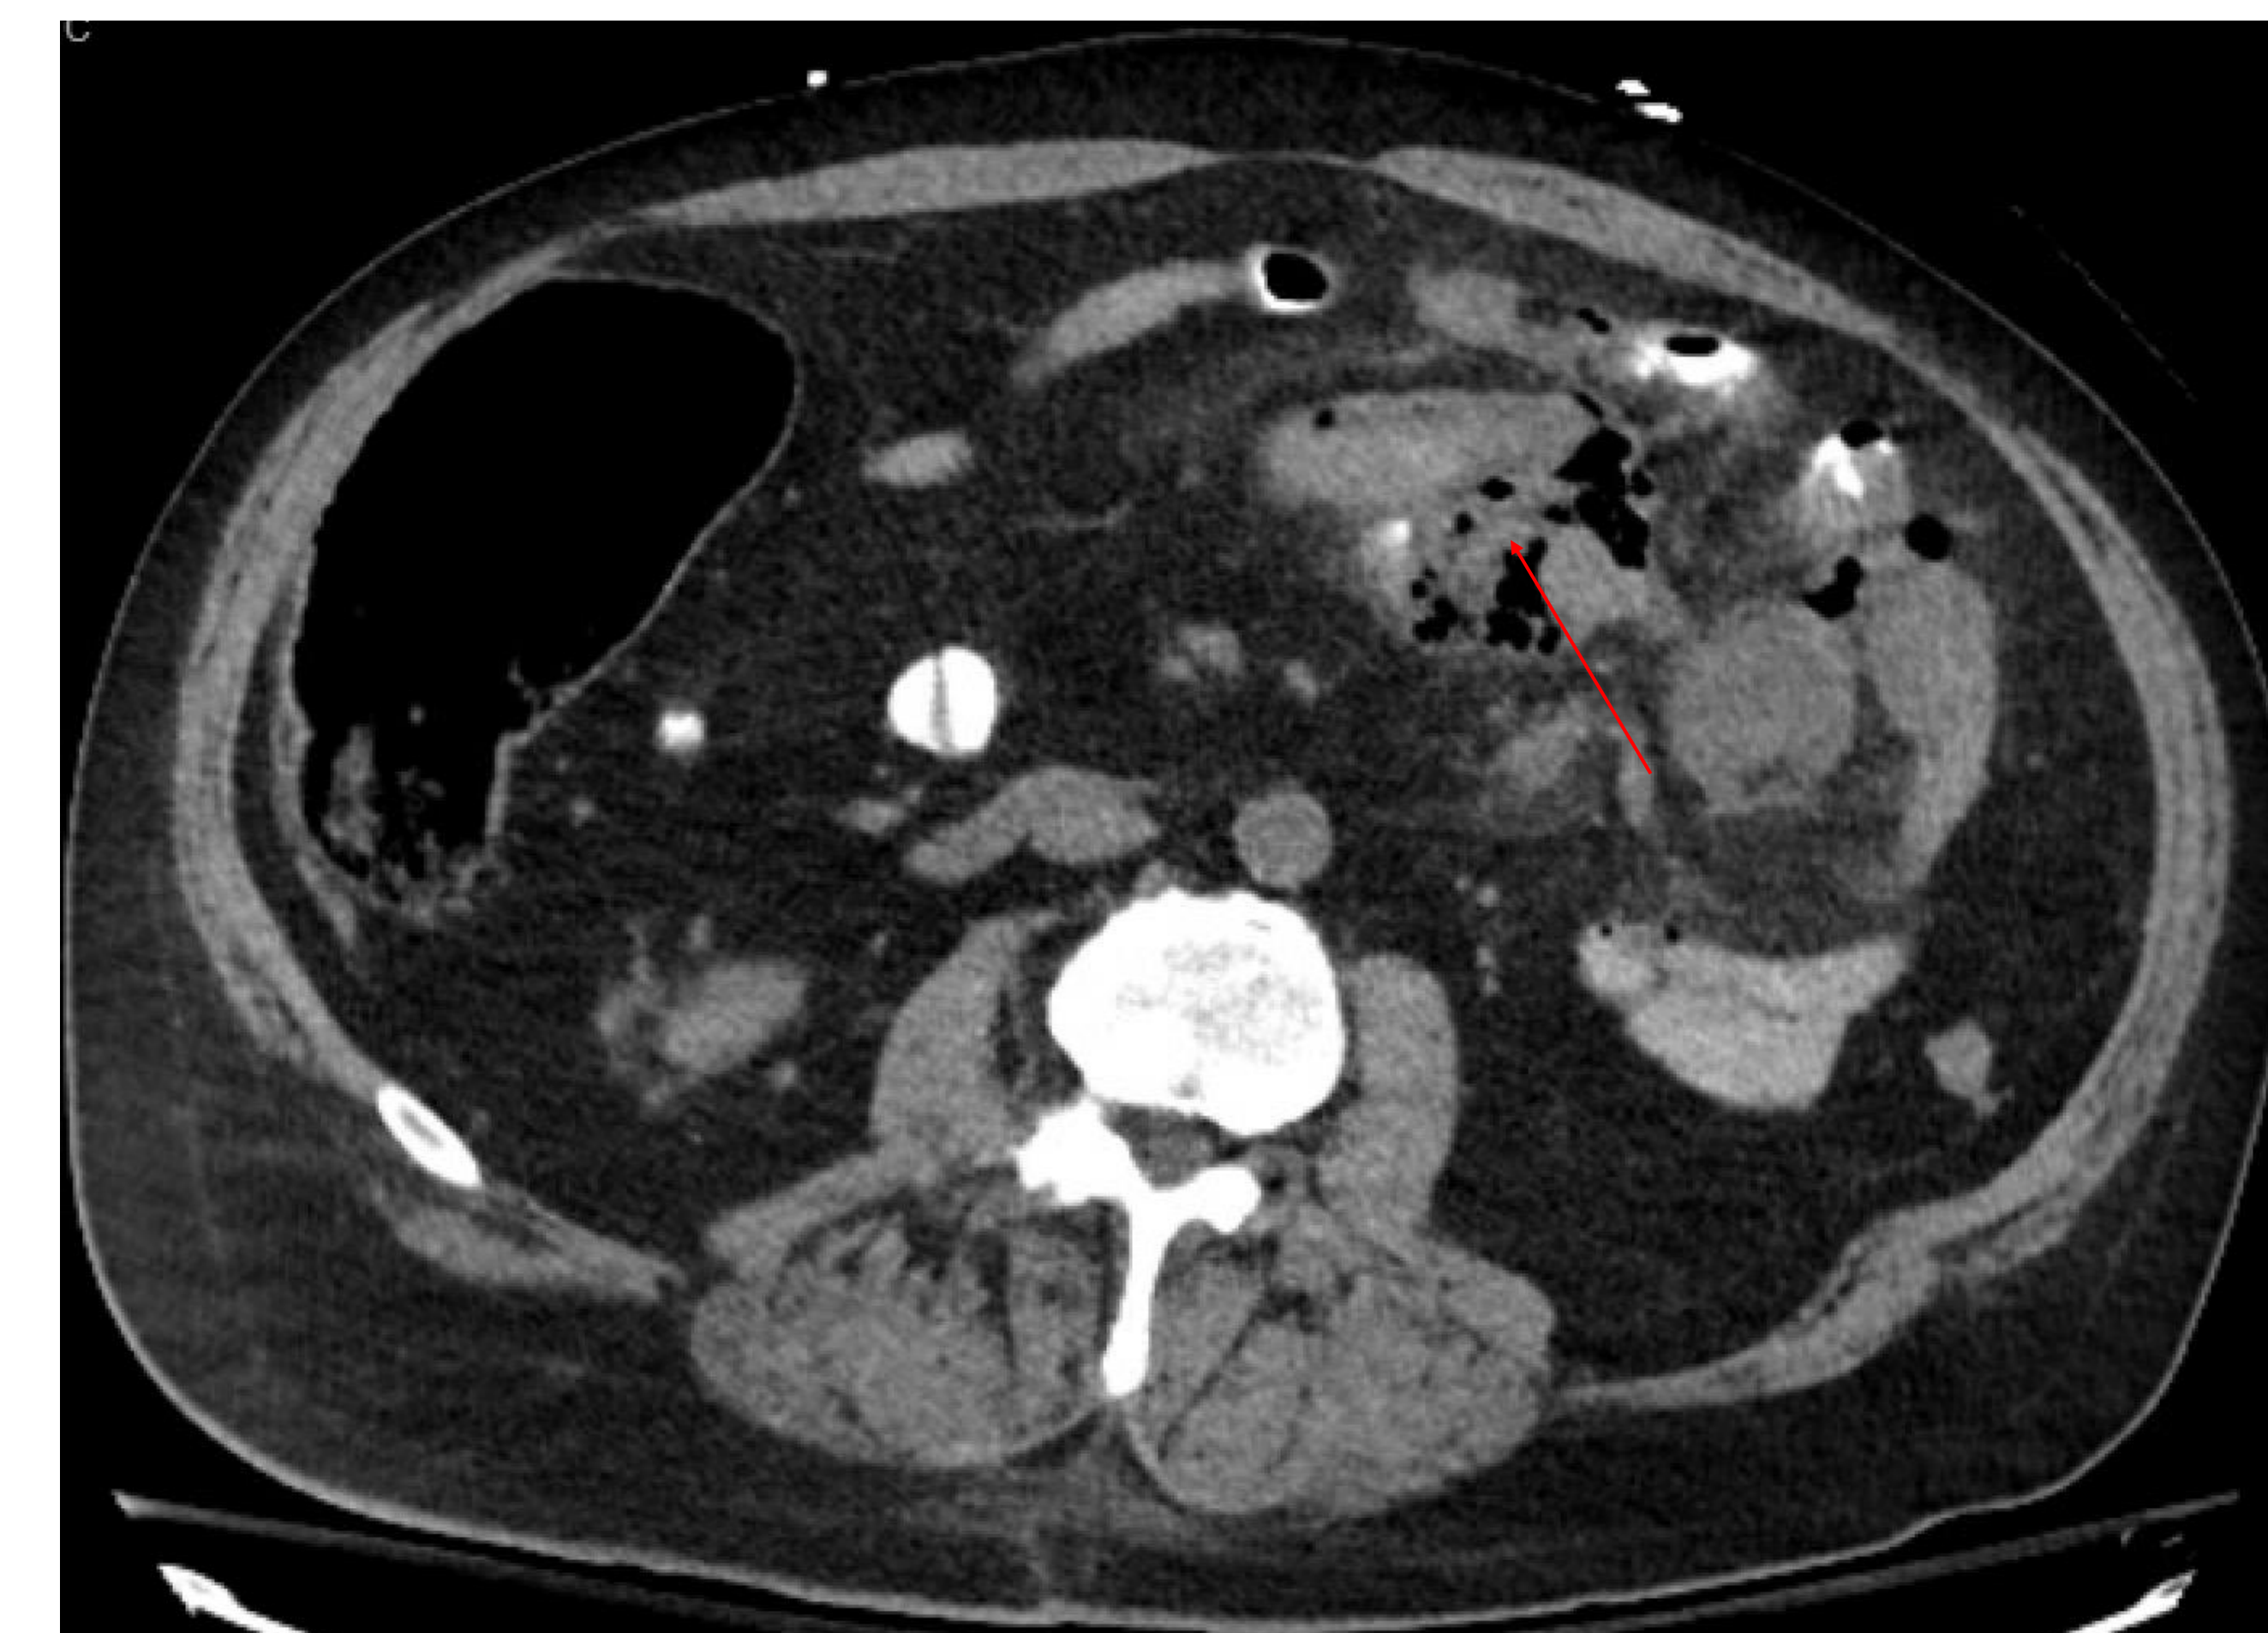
CT Abdomen/Pelvis transverse view showing thickened loops of jejunum with interloop abscess (arrow).
